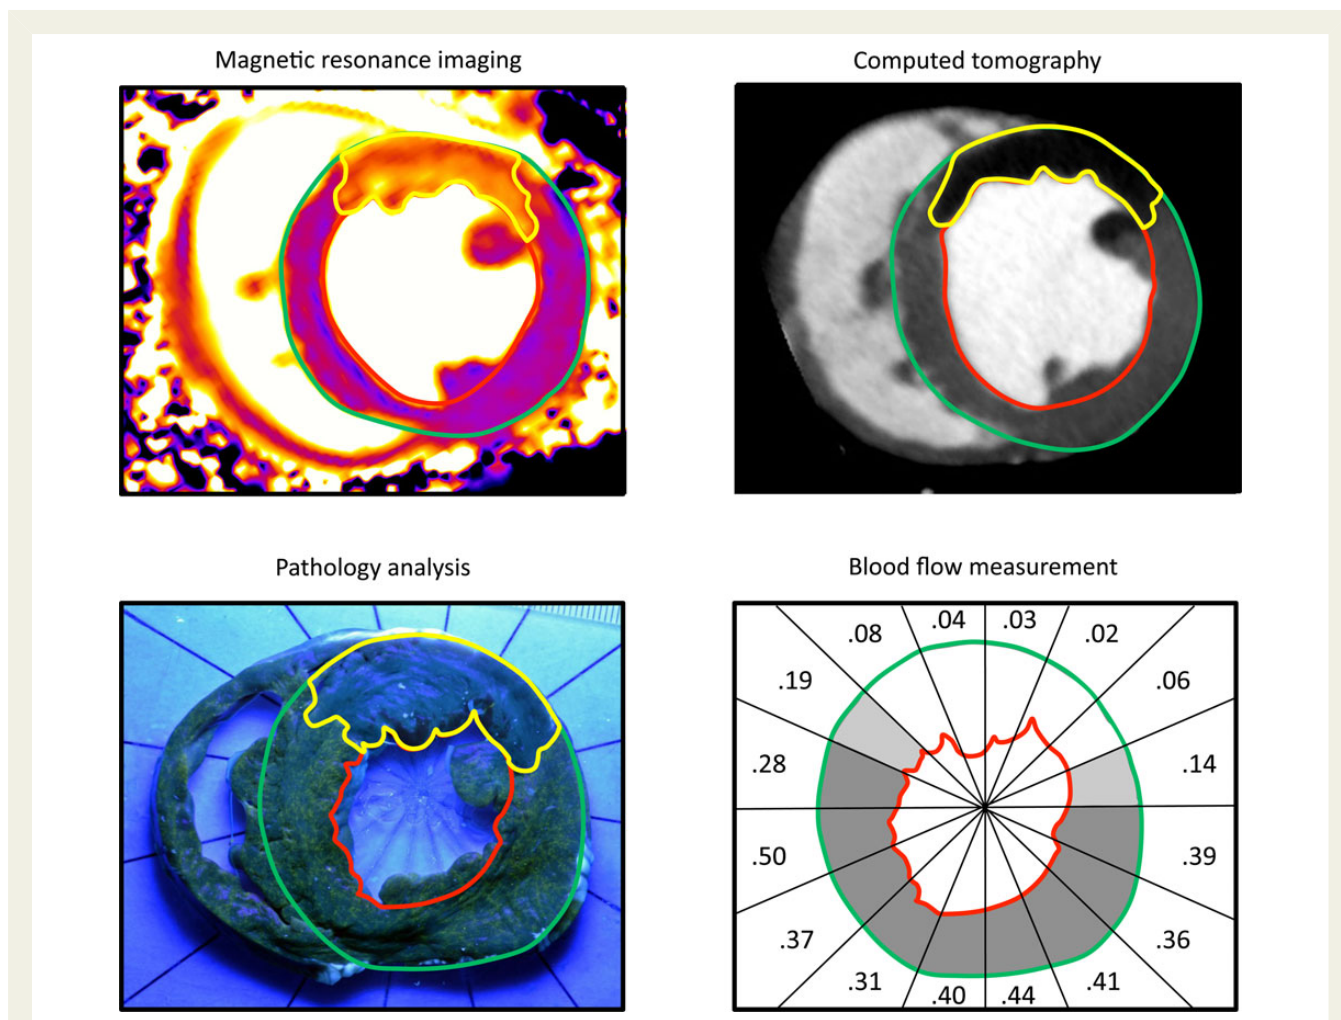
Spatial characteristics of the AAR. The mean AAR was similar for all imaging modalities (MRI:  $30 \pm 9$  vs. CT:  $31 \pm 7$  vs. Pathology:  $32 \pm 6$  vs. Microsphere blood flow:  $31 \pm 6\%$  LVM,  $P = \text{NS}$ ). The threshold for demarcation of the AAR was a difference of two standard deviations from the signal intensity or blood flow in remote myocardium for MRI, CT, and microsphere blood flow analysis. Pathology analysis was performed manually. The solid line denotes mean  $\pm$  SD.
